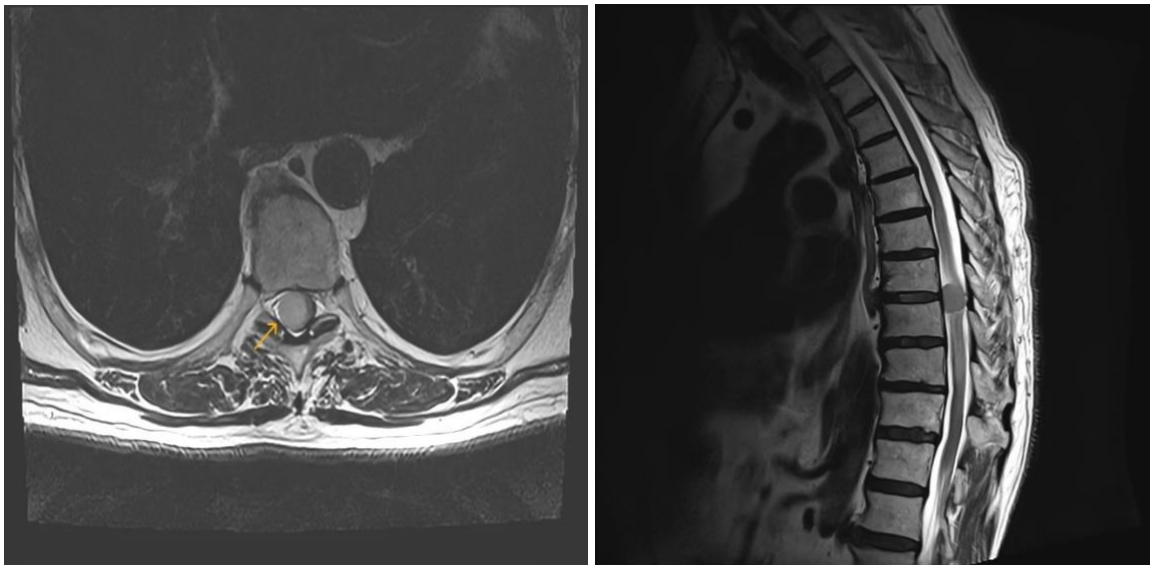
Axial and Sagittal T2 weighted MRI sequences: Intradural iso to hypointense lesion at T8-T9 level
